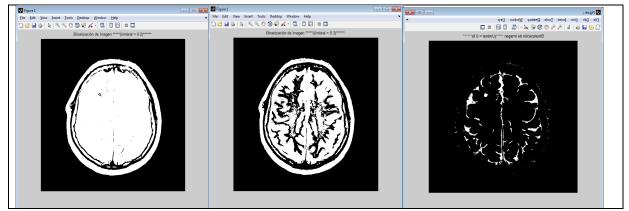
MRI images and the automatic process for select the threshold for to do the binary image.
